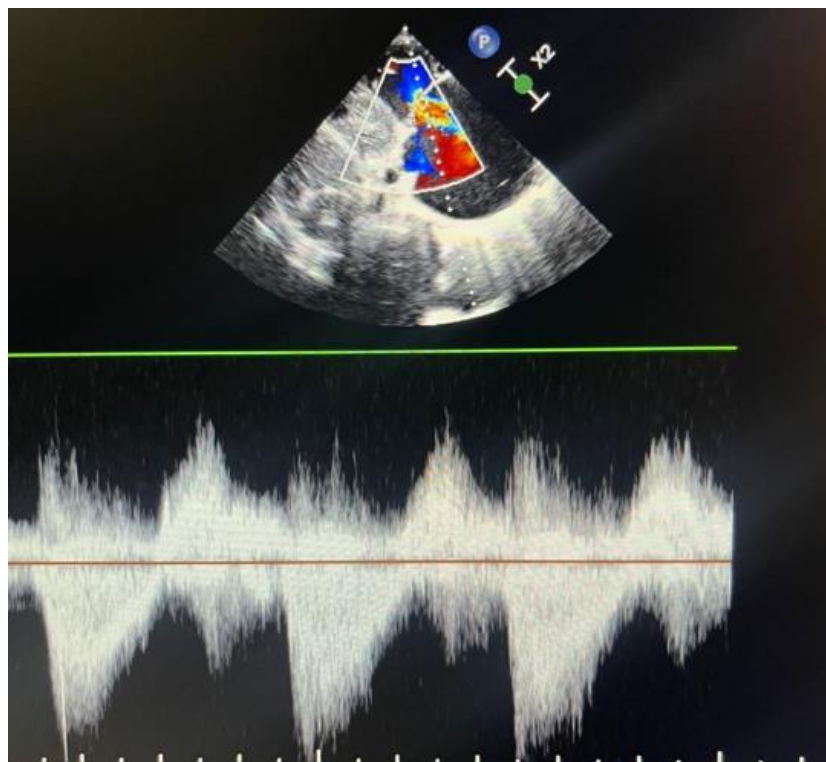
Continuous wave Doppler profile of severe tricuspid regurgitation showing the characteristic dagger shaped spectrum
